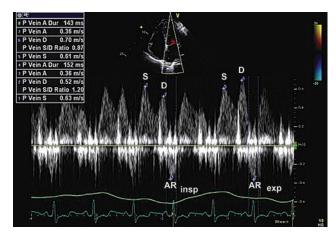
CP apical four-chamber view with PW Doppler of the right upper pulmonary vein in a patient with CP. The S (systolic), D (diastolic), and AR (atrial reversal waves) are noted. Respiratory variation of the D wave should be determined similar to the method used for the mitral E wave.
